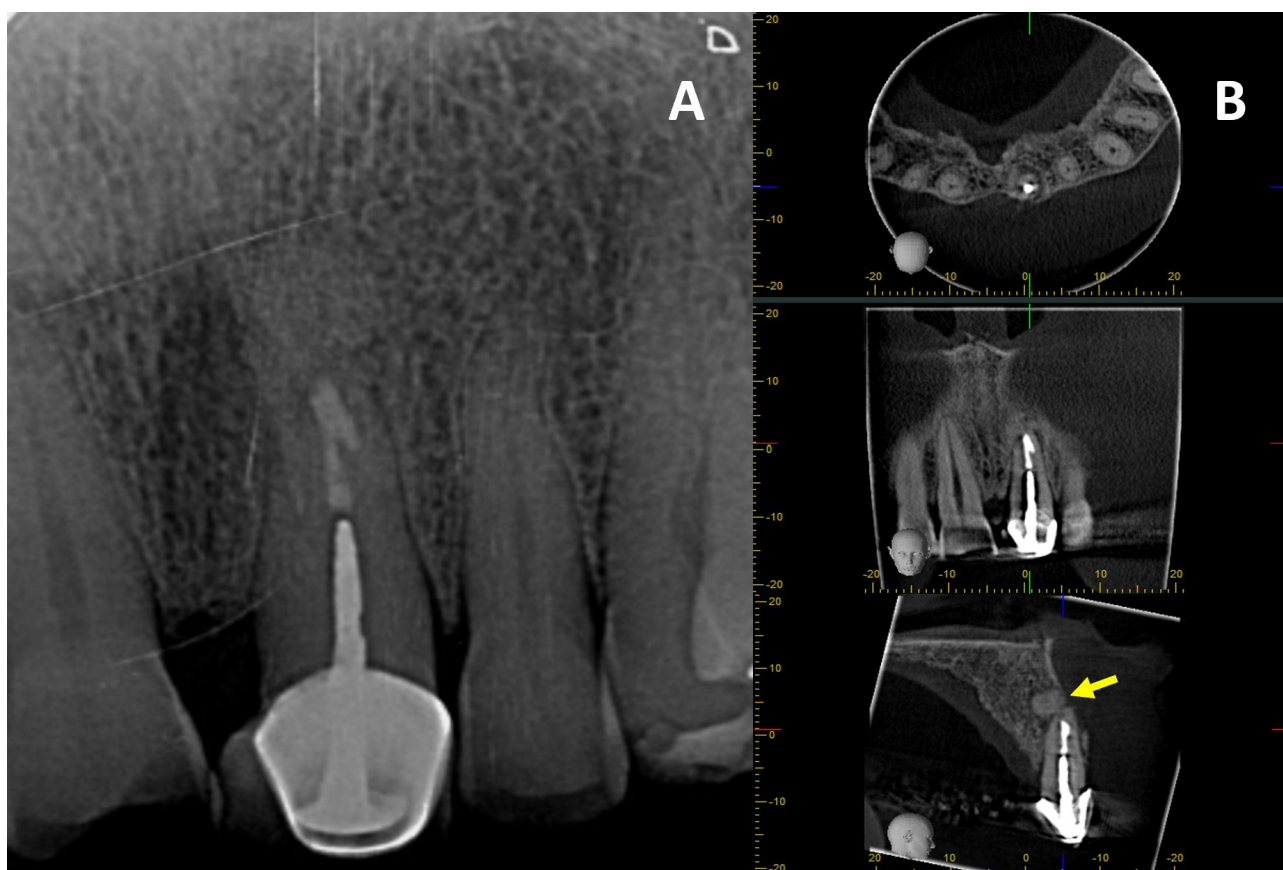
Healing findings: (A) Periapical radiograph at four months of follow-up; (B) Cone-beam computed tomography (CBCT) at eight months of follow-up. The sagittal section reveals a hyperdense image in the apical region, compatible with bone graft material (*yellow arrow*).
